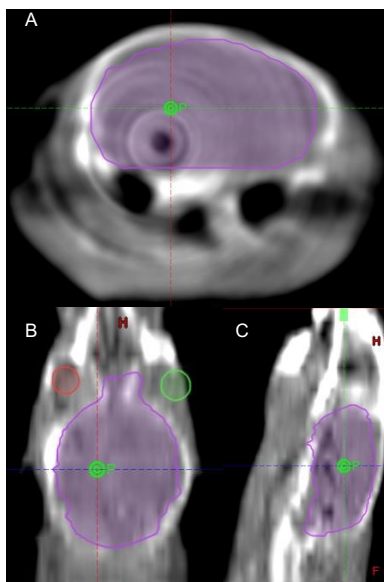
CBCT alignment. Cone beam CT (CBCT) images in Axial (A), Coronal (B) and Sagittal (C) views with isocenter and brain contours
